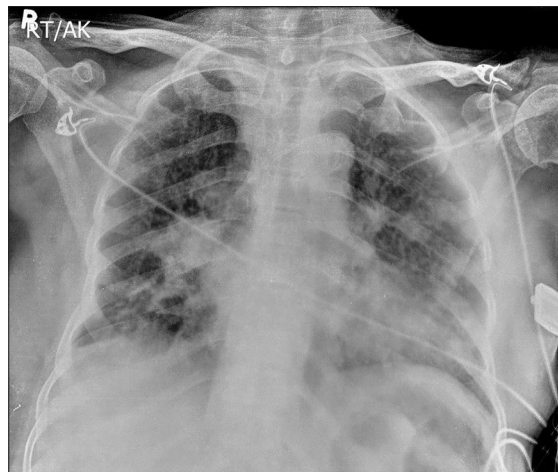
Chest radiograph shows patchy shadows in bilateral middle and lower zones
